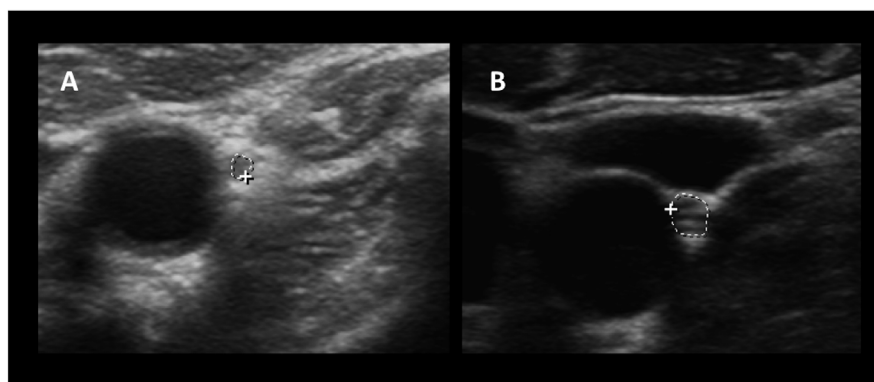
Ultrasound images of vagus nerve in a patient with amyotrophic lateral sclerosis (ALS) and a healthy control. (A) Cross-sectional area of the right vagus nerve in an ALS patient (0.011 cm²); (B) cross-sectional area of right vagus nerve in a healthy individual (0.04 cm²)
